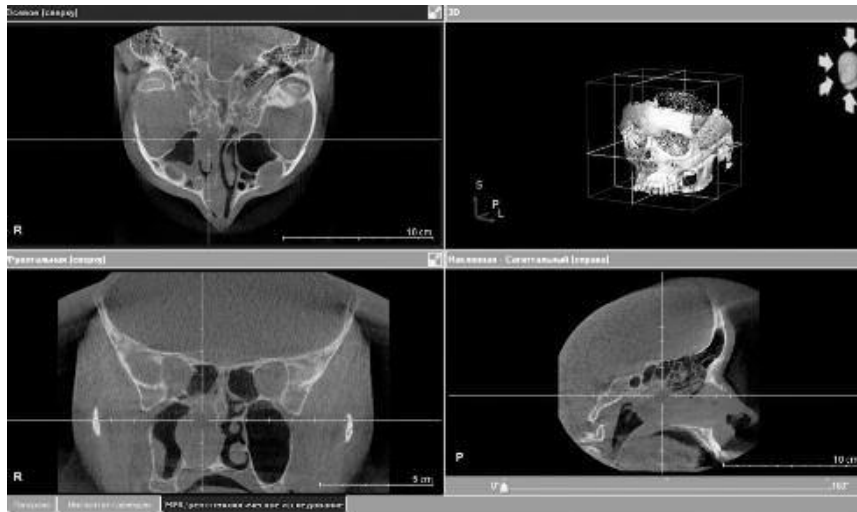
CT scan of the paranasal sinuses before surgery.
